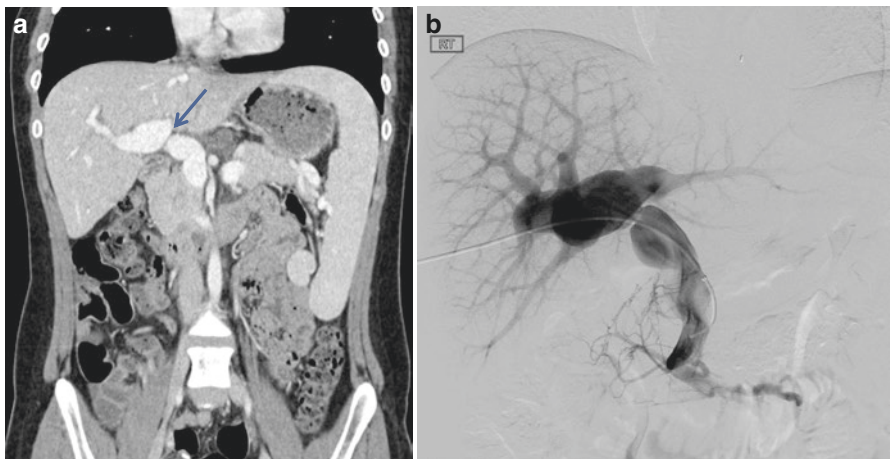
CT demonstrating portal vein stenosis followed by angiogram performed during balloon venoplasty
